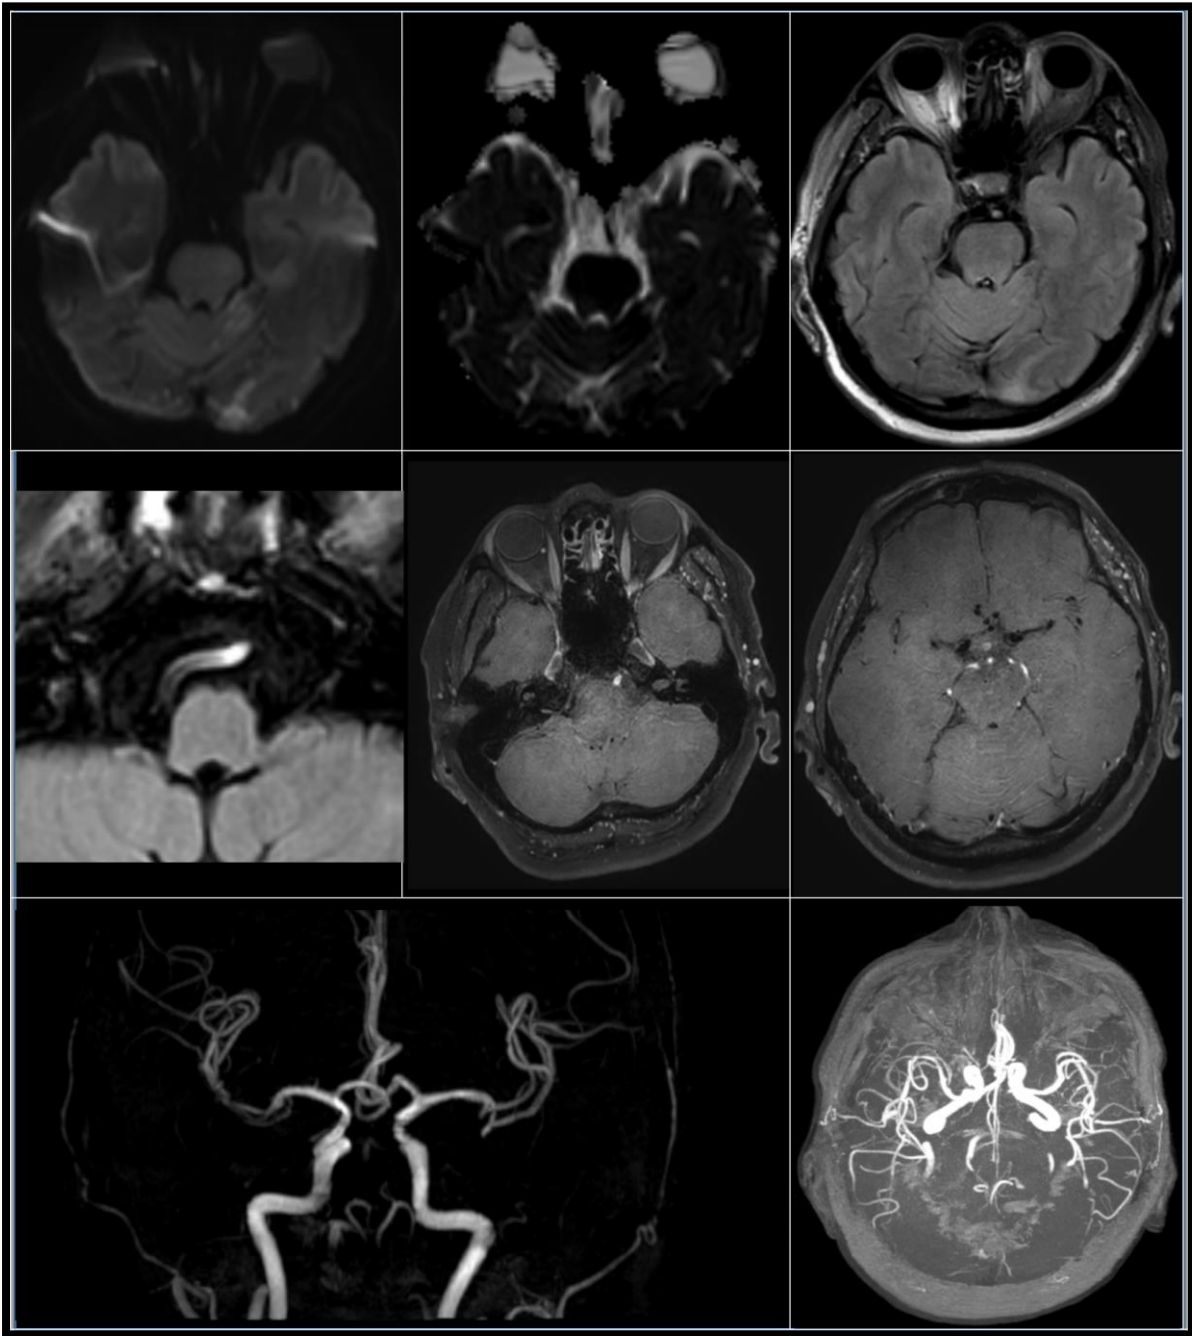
MRI showed acute bilateral posterior circulation infarction with full occlusion of the BA.
